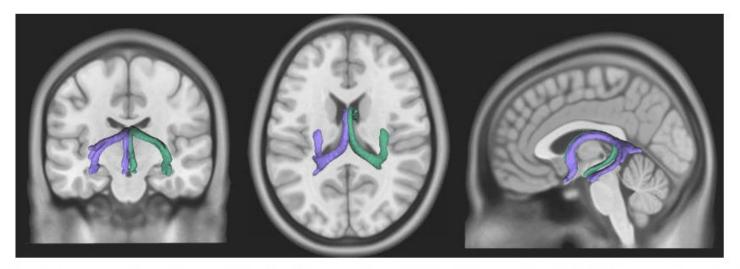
Three-dimensional representation of the fornix of a healthy adult subject. Coronal (left), axial (center) and sagittal (right) views, overlapped on a T1-weighted magnetic resonance image. DSI studio software was used for visualization (dsi-studio.labsolver.org).
